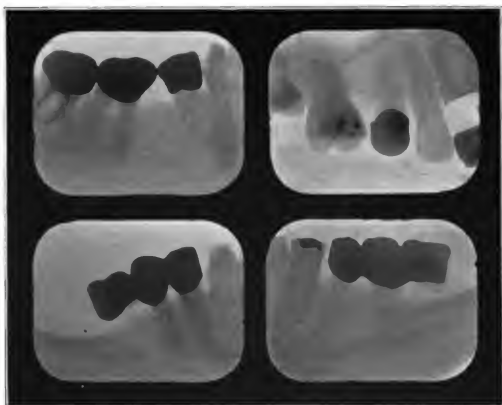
Radiographs showing cases where teeth have been crowned without devitalizing the pulps. The lower radiograph shows a right and left lower, one tooth extension bridge, both bridges in same mouth. The upper are bridges with live pulps in healthy condition, after fifteen years. Left lower radiograph shows a gold crown over tooth with live pulp, after twelve years. Right lower, gold crowns of teeth with live pulps after twenty-three years.
